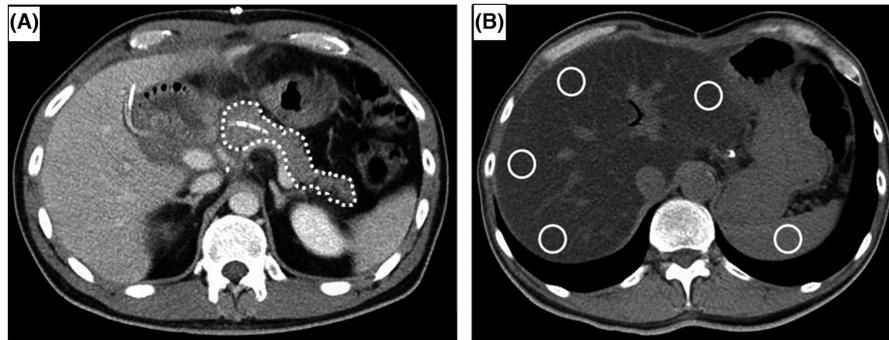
Representative computed tomography (CT) images showing the volume of remnant pancreas after pancreatoduodenectomy. A, Synapse Vincent software was used to evaluate the volume of the remnant pancreas (the area within the white dotted line). B, Mean CT attenuation values in four sectors of the liver and the median value of all the sectors of the spleen
